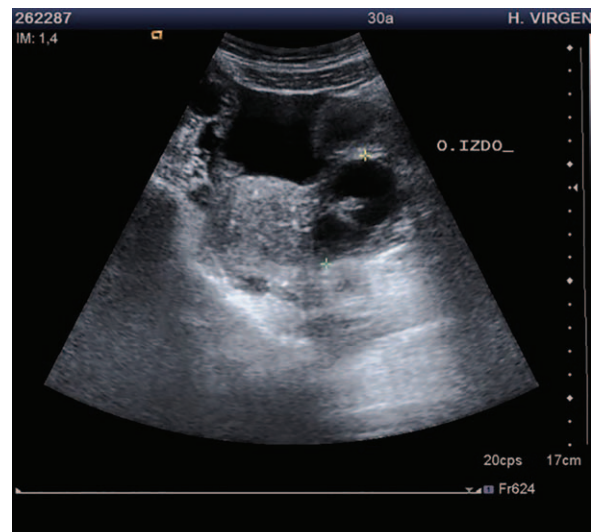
US—image compatible with 5 cm left ovarian teratoma. US=Ultrasound.
